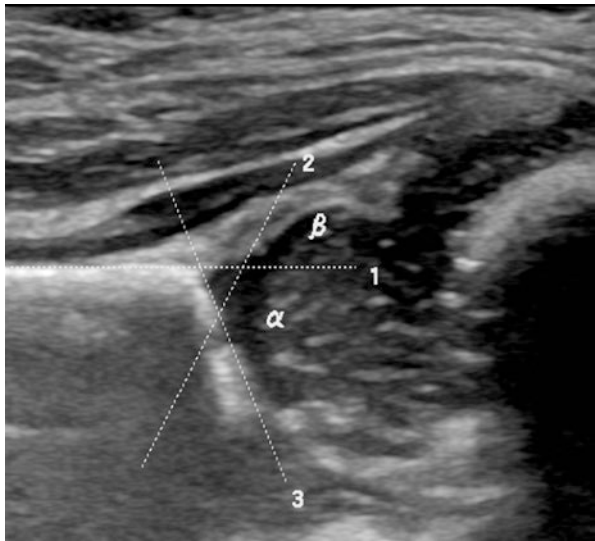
An ultrasound of a patient's left hip demonstrating the alpha (α) and beta (β) angles. Line 1, ilium; line 2, labrum; line 3, acetabulum
